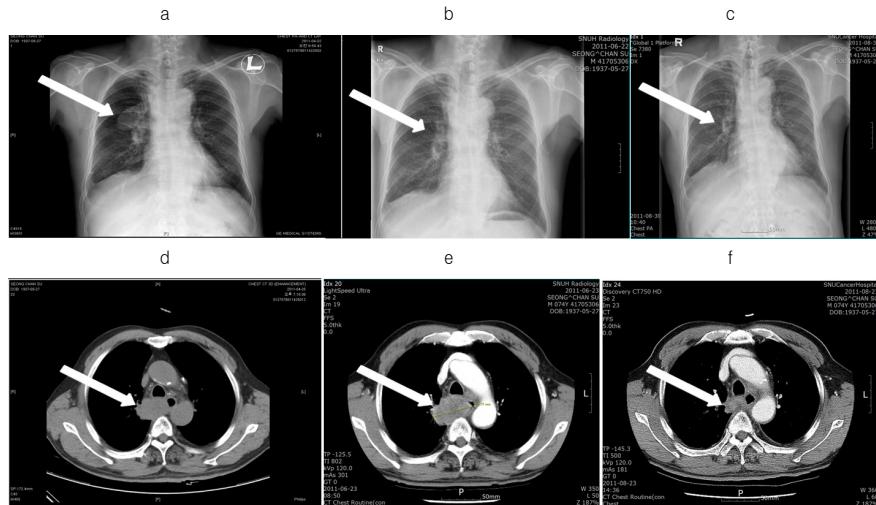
Radiographic Images of Chest PA X-ray and CT Before and After Treatment with *Gunreyngtang-gagambang* and Chemotherapy.
